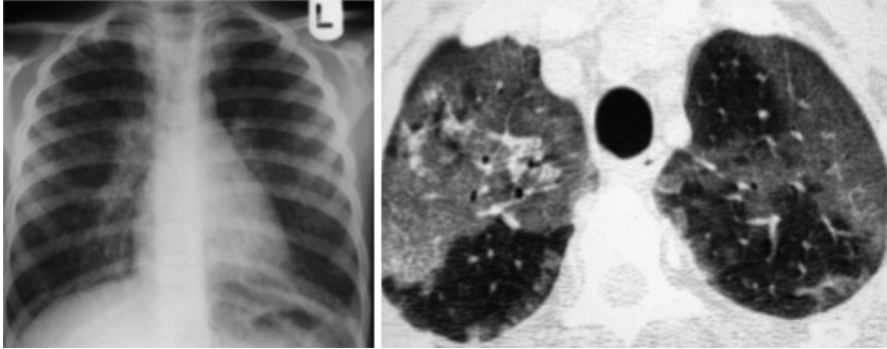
Interstitial pneumonia. CXR shows subtle ground glass and fine reticular pattern. These features are more readily appreciable on the HRCT where there are patchy bilateral centrilobular opacities
